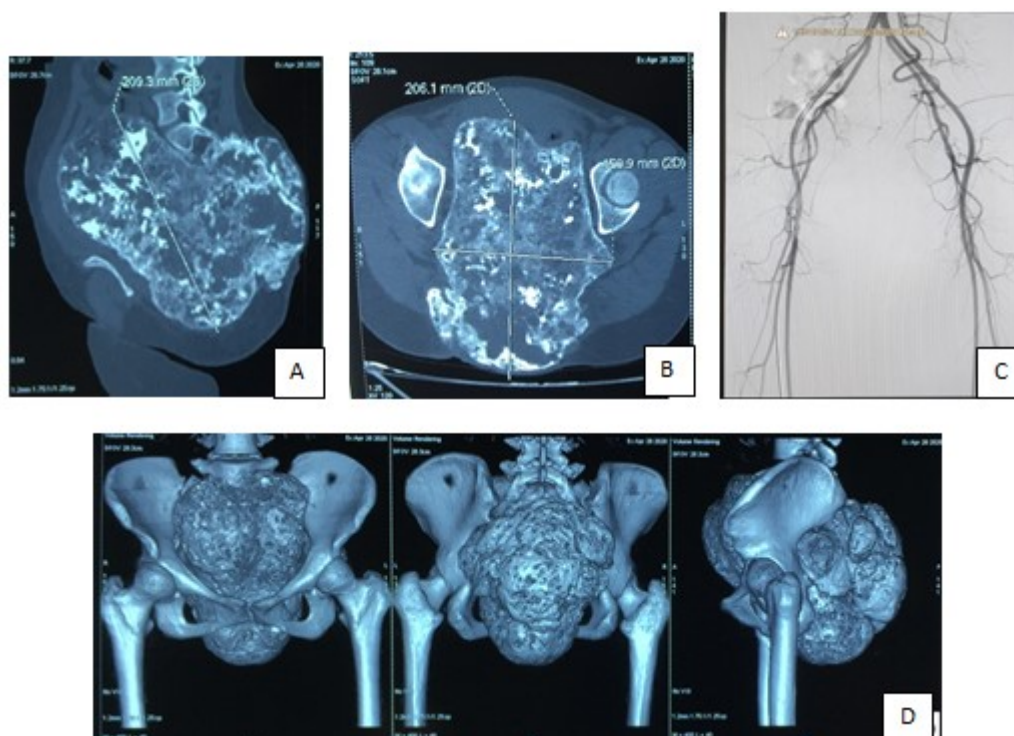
A, B: Sagittal and coronal views CT scan of the tumor. CT scanner: The tumor originated from S2 into the sacrum measuring 210 × 150 × 210mm in size, with a hyperdense material, a well-demarcated image including sacrococcygeal bone destruction. Organs in the pelvic were displaced into the ventral space and there was no evidence of encroachment. The right kidney was atrophied due to tumor compression. There was no image of lymph nodes in the pelvic region. C: DSA image of the tumor's supplied blood vessels. D: Three-dimensional image of the tumor on computer tomography.
